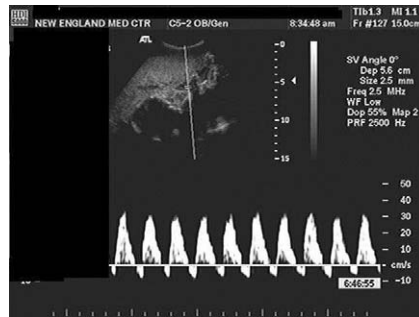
Color Doppler of the umbilical artery showing reversed end-diastolic flow.
